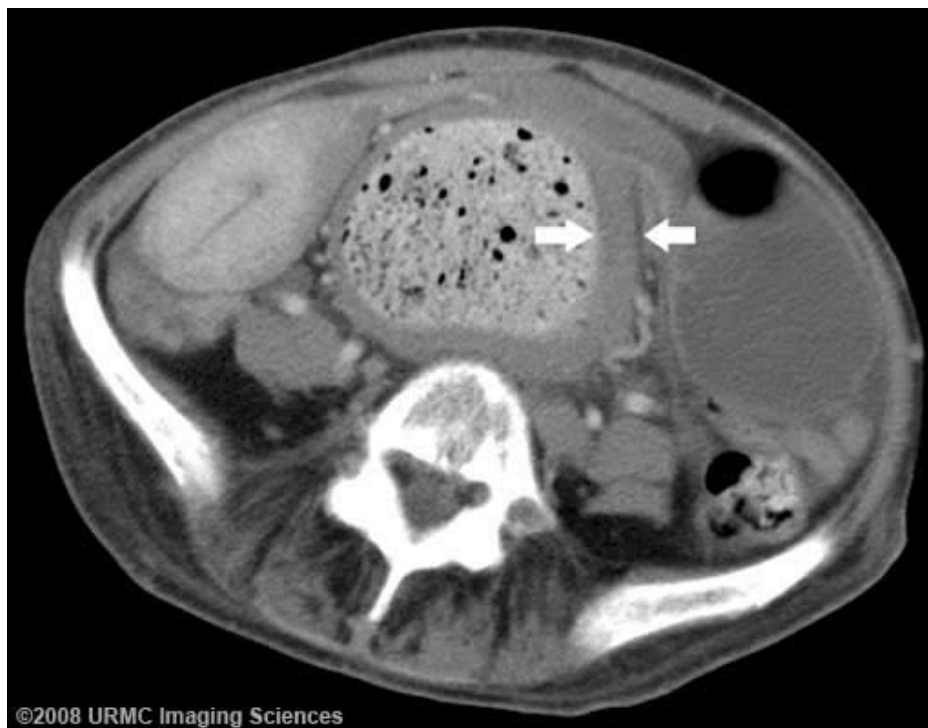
(Case 2): CT at the level of the pelvis demonstrates a large fecolith in the sigmoid colon. There is diffuse colonic wall thickening (arrows), concerning for stercoral colitis.
